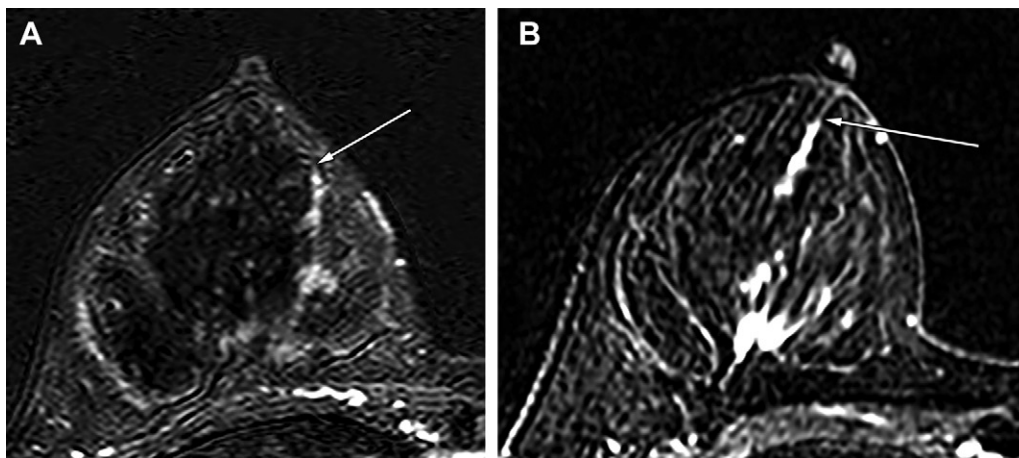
MRI scans in a 35-year-old woman with triple-negative breast cancer who did not have nonmass enhancement (NME) extension to the nipple at MRI before neoadjuvant chemotherapy (NAC), but who presented with NME extension at MRI after NAC. This patient was administered four cycles of anthracycline and cyclophosphamide every 3 weeks, followed by 12 cycles of weekly paclitaxel. (A) MRI scan before NAC shows NME not extending to the nipple (arrow). (B) The NME stretching the nipple-areolar complex at subareolar lesion is newly observed on the MRI scan acquired after NAC (arrow). The presence of tumor invasion of the nipple was confirmed at pathologic evaluation.
